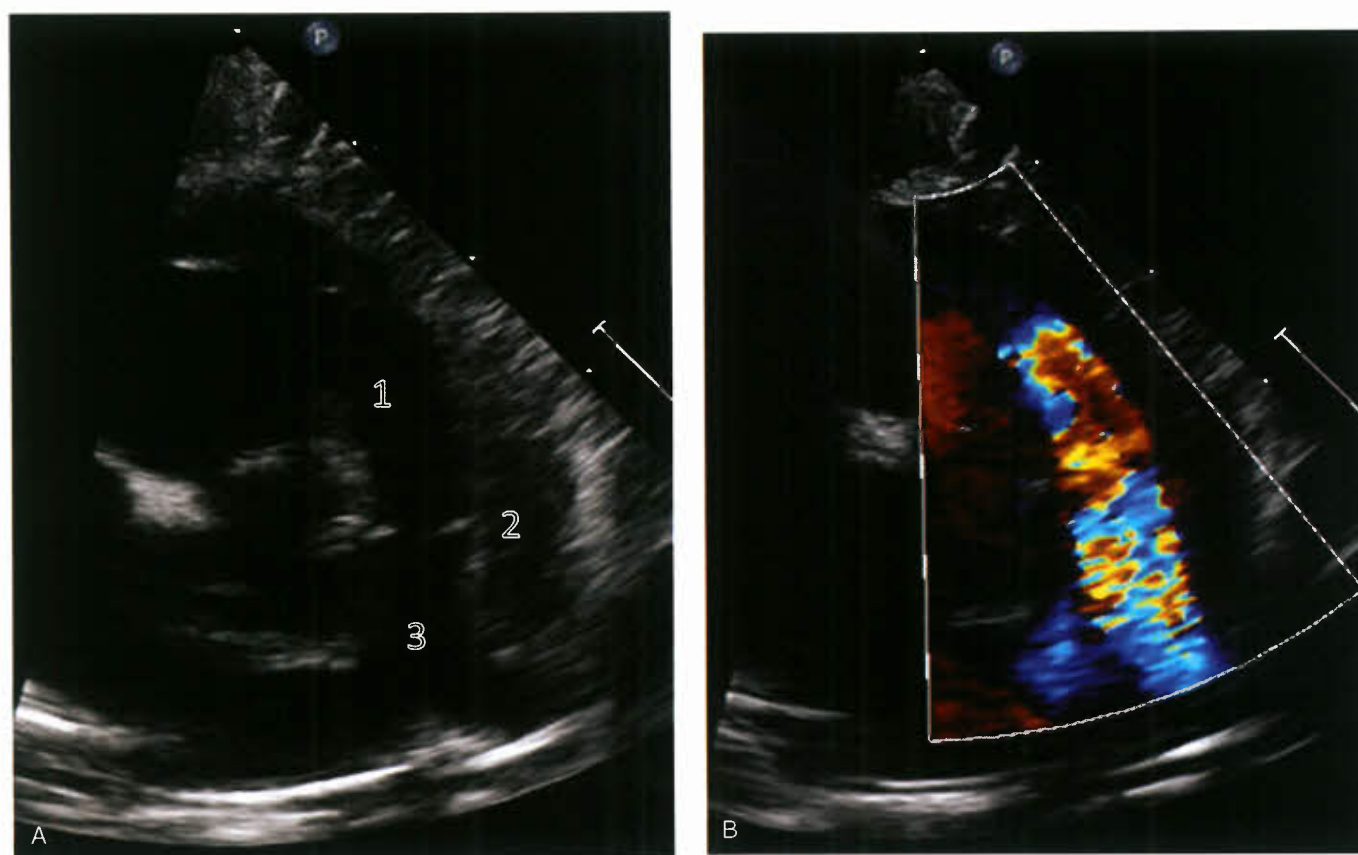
There is potential for multilevel obstruction of the RV outflow tract. This can occur because of (1) subpulmonary infundibular obstruction, (2) valvular pulmonary stenosis, and (3) branch PA stenosis. The RVOT is best imaged in a parasternal short axis view. Color flow Doppler can be used to demonstrate both the location and severity of obstruction.
